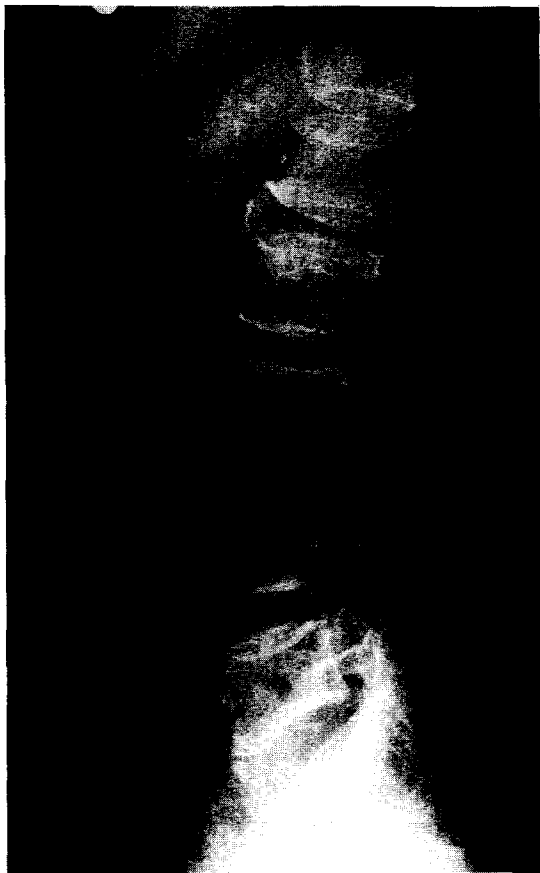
Lumbosacral plain radiography shows marked atherosclerotic calcification on abdominal aorta.
